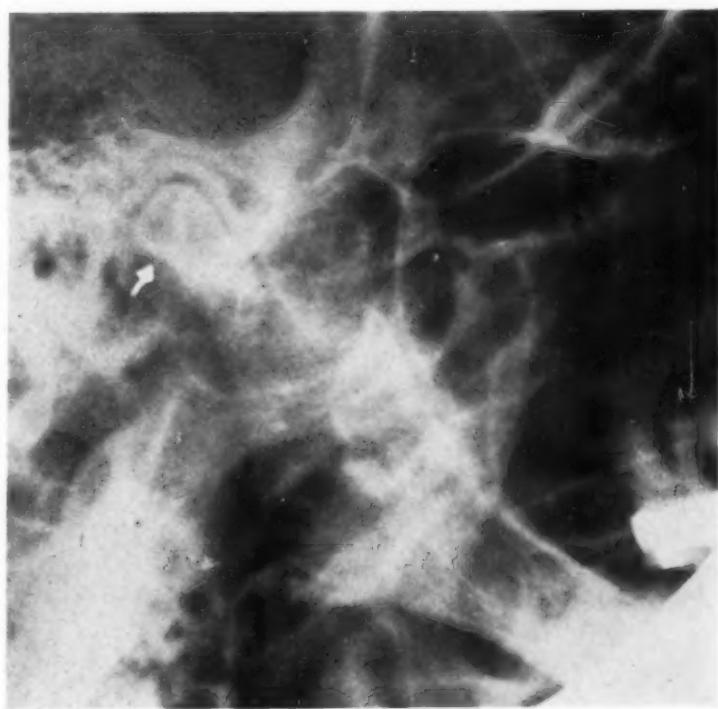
X-ray film of normal condyle on left side.
